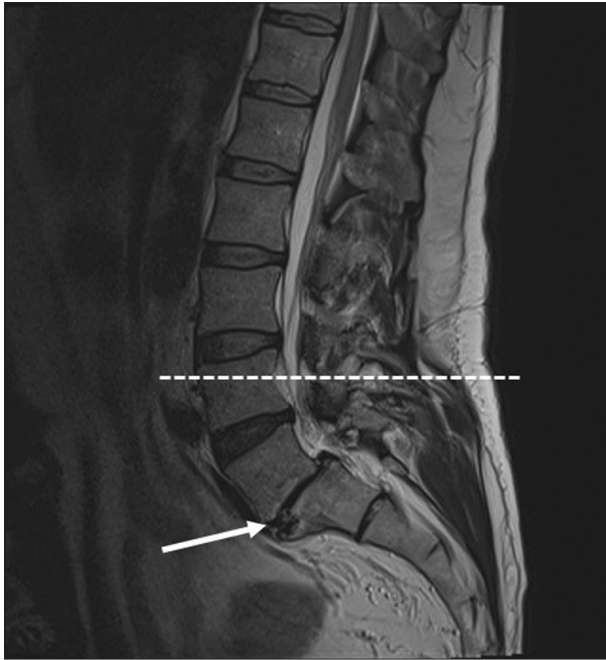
Sagittal view of T2-weighted magnetic resonance imaging of the lumbar spine indicating disc bulging at L4–L5, pronounced degenerative disc disease at L5–S1 with pseudo-bulging caused by degree one anterolisthesis (white arrow). Biopsy level is indicated (dotted line).
